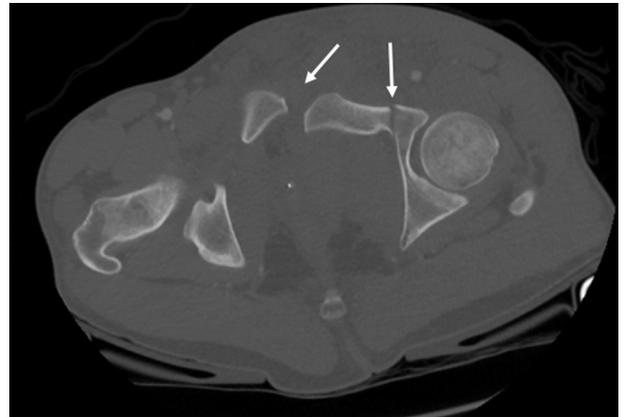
Axial CT of the pelvis in Grade II anteroposterior compression injury: diastasis of pubic symphysis and left pubic ramus fracture with posterior displacement of ramus fragment.
